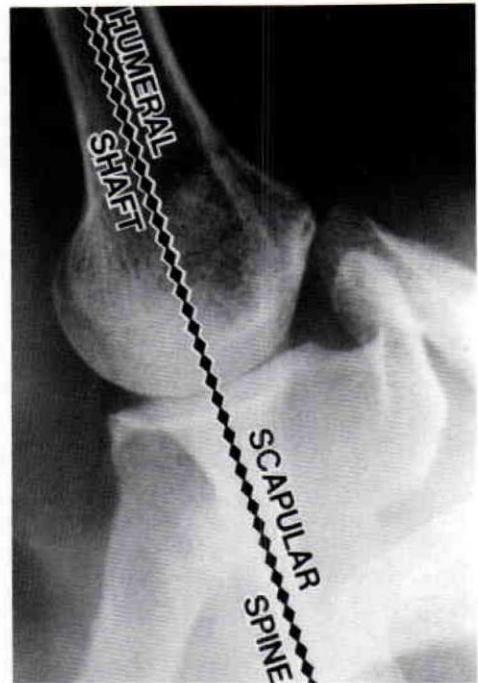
Roentgenogram showing the normal shoulder joint in the zero-position.
